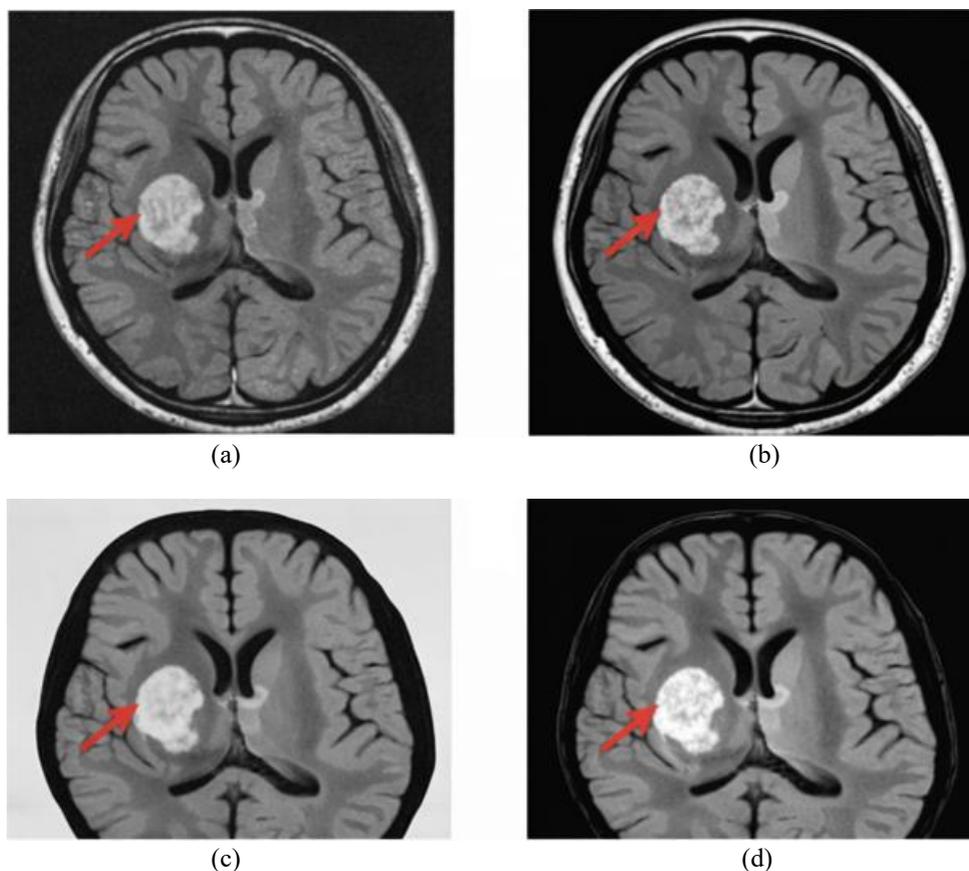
Effect of Intelligent Preprocessing on MRI Images (a) Original MRI (b) Denoised MRI (c) Skull-Stripped Image (d) Contrast Enhanced Image
